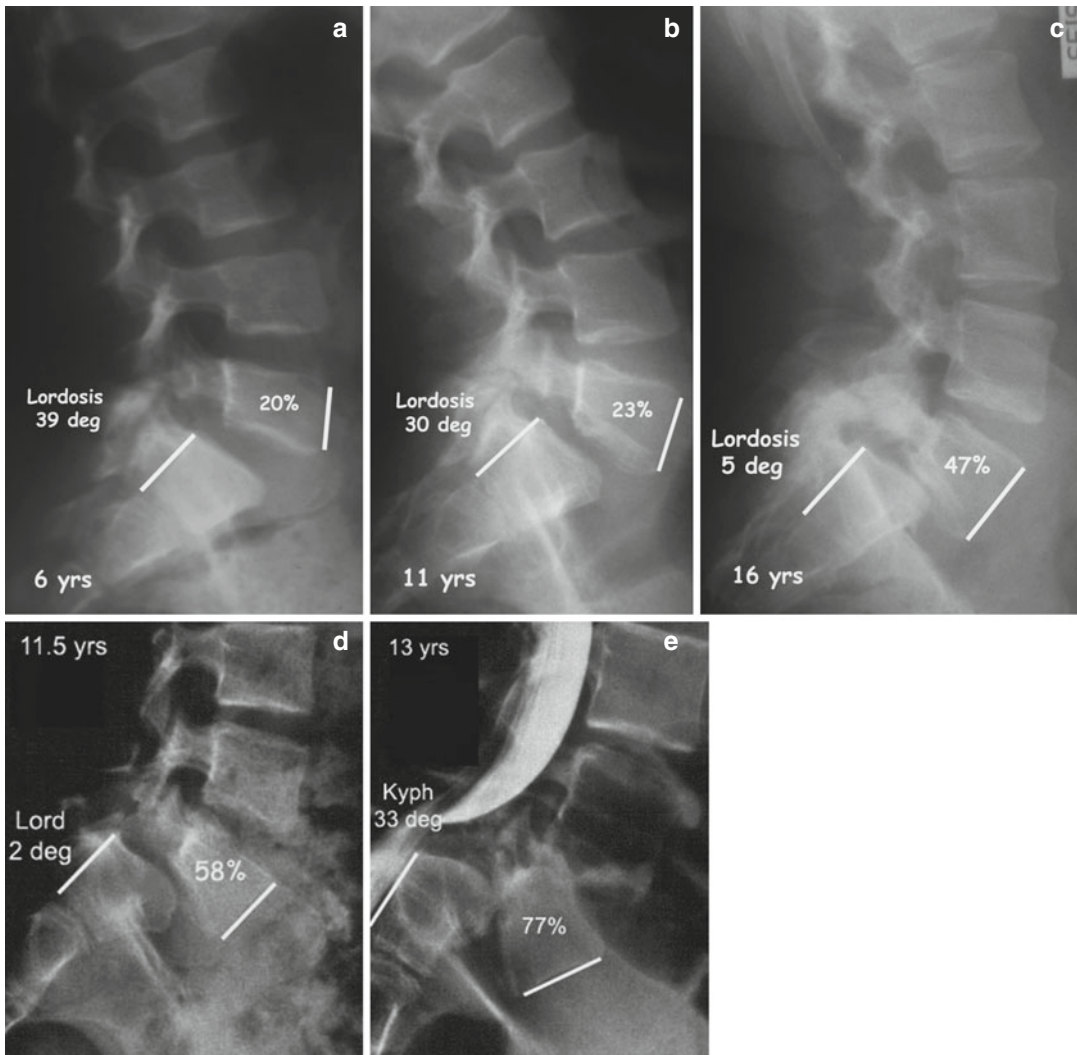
Radiographs demonstrating changes of lumbo-sacral alignment during slip progression. Standing lateral radiographs of a female patient at 6 years of age (a), 11 (b) and 16 (c) years show marked loss of the physiologic
